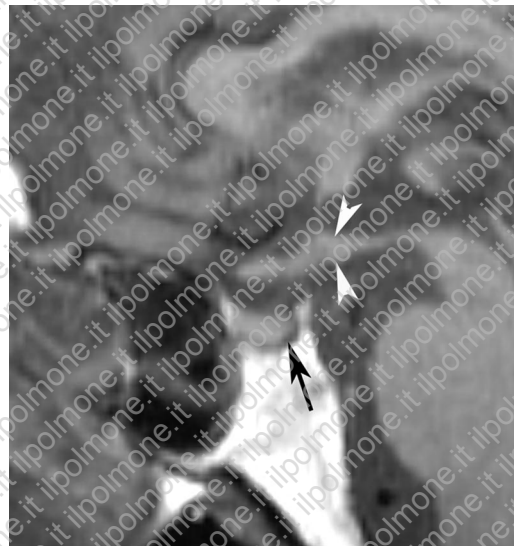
Neurosarcoidosis. Midsagittal T1-weighted MR image obtained in the same patient as in Figure 12 reveals an enlarged hypothalamus (arrowheads) and loss of the high signal intensity normally seen in the posterior pituitary lobe (arrow).
